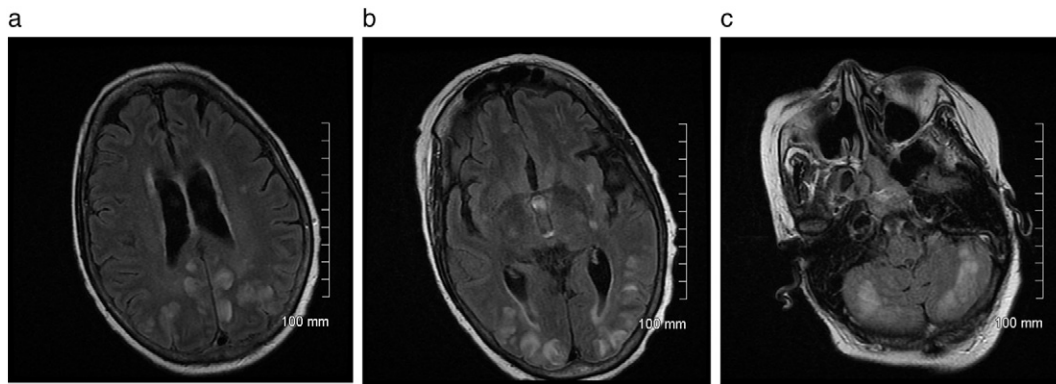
63 year old female with high grade serous ovarian carcinoma who developed predominantly subcortical and cortical T2 hyperintense foci in the frontal, parietal, temporal, and occipital lobes as well as cerebellar hemispheres, as demonstrated on these T2 FLAIR images (a, b, c). T2 hyperintense foci were also noted in the pons (not pictured). Findings were consistent with posterior reversible encephalopathy syndrome (PRES).
